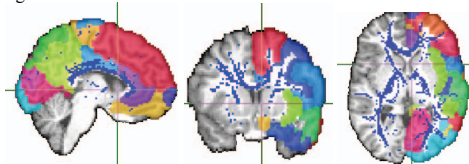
Cortical surface labels from a representative subject's left hemisphere are overlaid on sections from the same subject's 3D T1-weighted image. The EPI-corrected map of the fiber density is also overlaid. This shows that the DWI-derived fibers are accurately registered to the structural scan.
